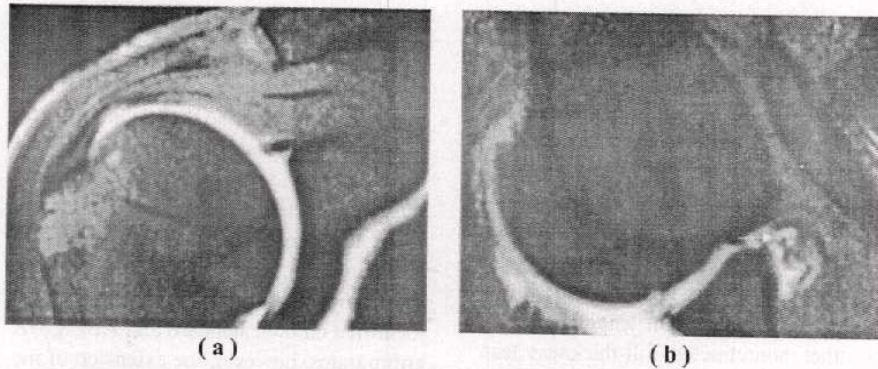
Detection of a superficial undersurface tear of the rotator cuff with the ABER position in a 19-year-old baseball player who had pain related to overhead motion of his arm. (a) Standard oblique coronal T1-weighted fat-saturated MR arthrogram showing no abnormality of the rotator-cuff tendon, (b) ABER T1-weighted MR fat-saturated MR arthrogram at the corresponding level of the rotator-cuff tendon in (a) revealing an undersurface tendon irregularity (arrow) enhanced with contrast material which was demonstrated by arthroscopy to represent a grade-I tendon-cuff tear.
